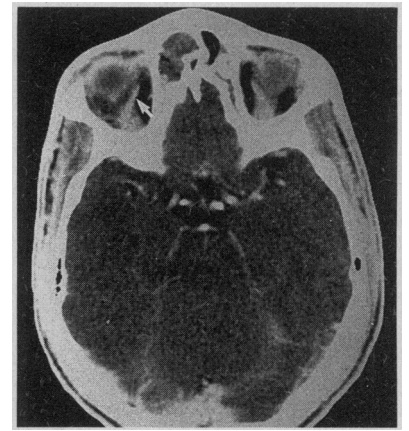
Axial computed tomographic scan of the brain (April 20, 1989) shows recanalization of the right superior ophthalmic vein (arrow).
